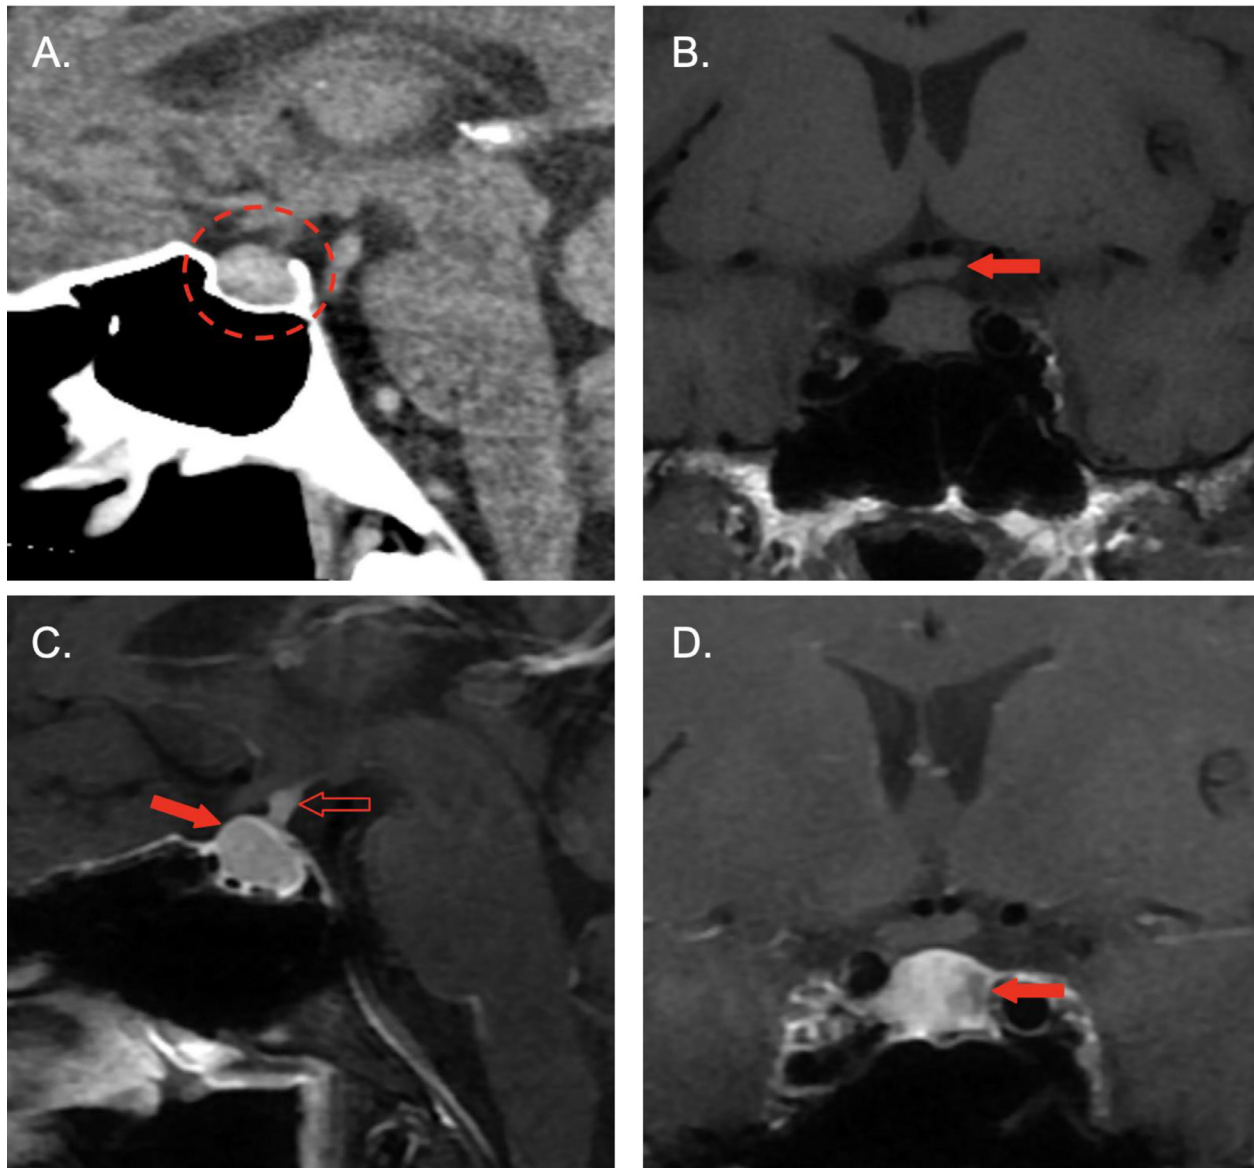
(A) Sagittal noncontrast CT of the head demonstrates a hyperattenuating pituitary gland with a superior convex margin (dashed circle). (B) Coronal T1 MRI sequence shows no mass effect of the enlarged pituitary gland on the optic chiasm (solid arrow). (C) Sagittal fat-suppressed T1 postcontrast MRI sequence demonstrates an enlarged anterior pituitary gland (solid arrow) and normal enhancement of the infundibulum (open arrow). (D) Coronal fat-suppressed T1 postcontrast MRI sequence reveals a region of heterogeneous enhancement in the left aspect of the anterior pituitary gland (solid arrow).
